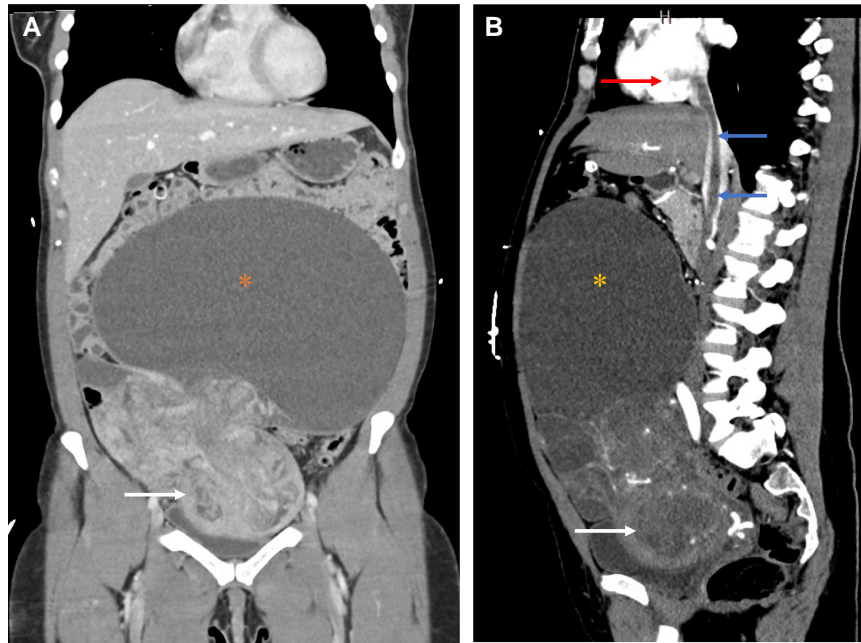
Computed tomography of the chest, abdomen, and pelvis with intravenous contrast. A mixed solid and cystic exophytic mass $\sim 13.7 \times 13.6 \times 12.1$ cm arising from the pelvis (white arrow marking the uterus) with a cystic component (*), measuring $\sim 24.8 \times 12.0 \times 16.4$ cm, extending into the epigastric region. (A) Coronal view. (B) Sagittal view. A non-occlusive filling defect in the inferior vena cava (blue arrow) extending into the right atrium (red arrow).
